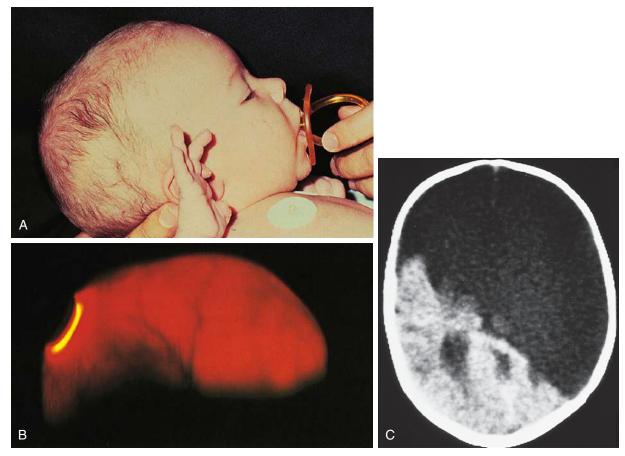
Hydranencephaly. A, Patient, age 3 weeks, has a deceptively normal appearance with little to suggest a severe brain abnormality. B, Transillumination of the skull lights up the entire calvarium, suggesting the diagnosis. C, CT scan demonstrates replacement of the cerebral hemispheres by a large, water-dense cavity with residual islands of brain tissue in regions of the occipital poles and right inferior temporal lobe. (C, *Courtesy Division of Neuroradiology, University Health Center of Pittsburgh, Pa.*)
